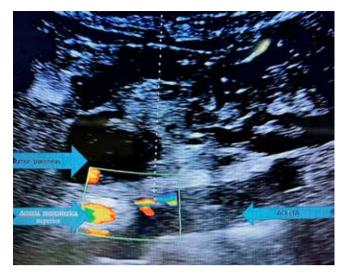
Ultrasound Doppler navigation during neurolysis. The tumor and large arteries are marked. Uneven spread of anesthetic laterally from the celiac plexus projection (not represented in this projection)
